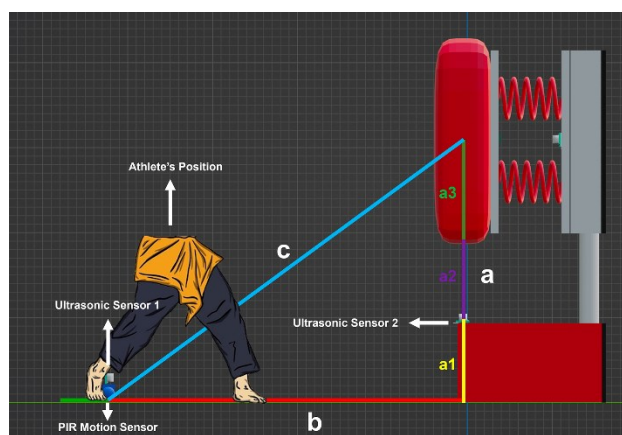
Construction of ultrasonic sensor and PIR motion sensor
